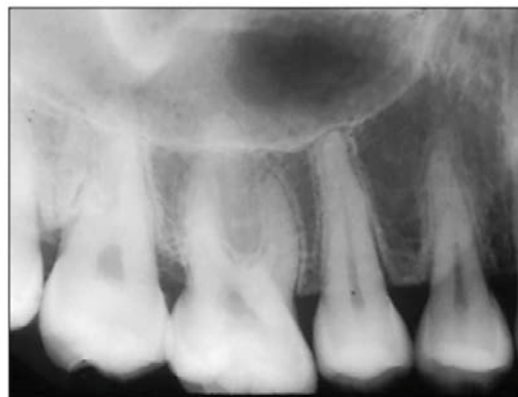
Periapical radiograph of showing the LD and PDLS.
